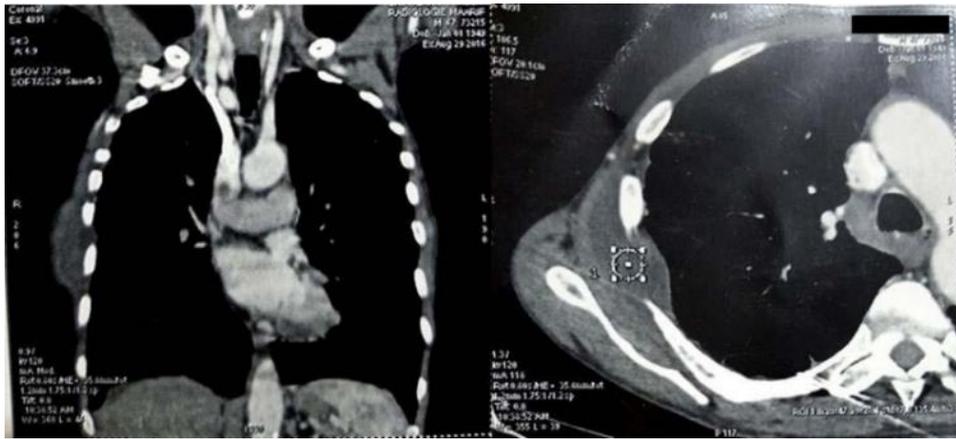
CT scans showing a right parietal abscess with bone lysis
